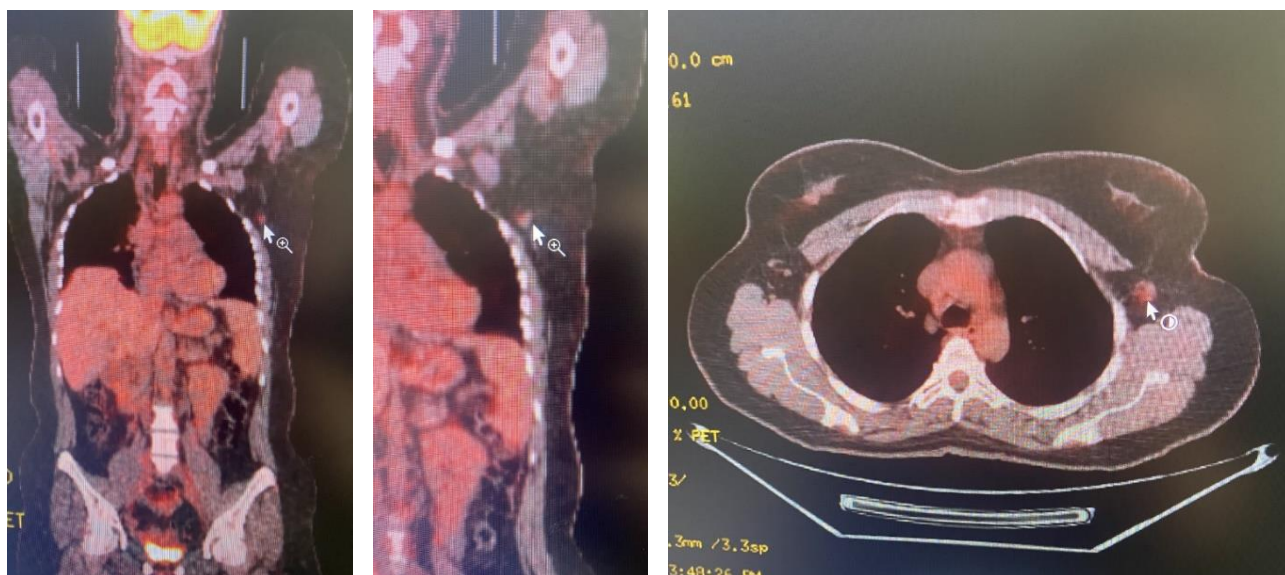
Positron emission tomography-computed tomography examination, a pathological lymph node in the left axillary region
